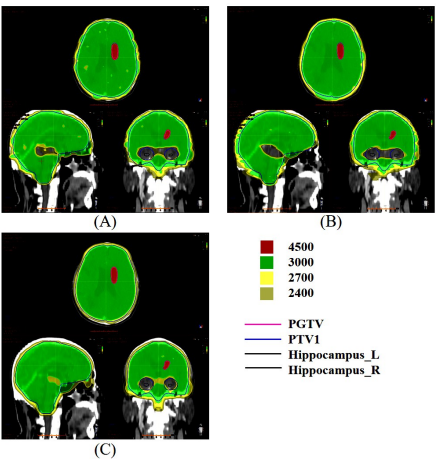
CT images of dose distribution of IMRT, VMAT and HT in brain metastases ((A) IMRT (B)VMAT (C)HT).
